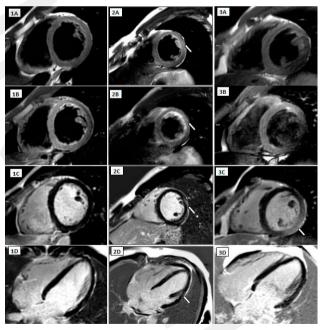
Panel A – SAX T2-weighted images, panel B – T2 STIR images, Panel C – SAX LGE images, Panel D – HLA LGE images.
